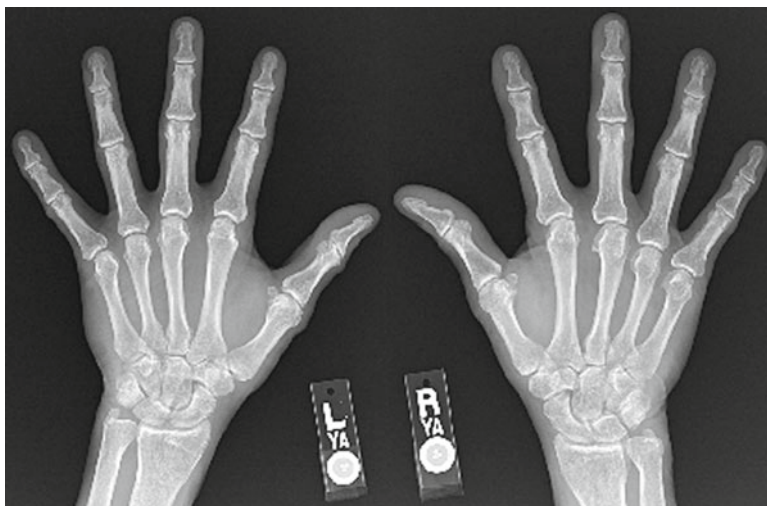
Osteophytes (right second DIP, bilateral fifth DIPs), degenerative joint disease without the presence of erosions (right second, third, and fourth DIPs), and joint space narrowing (bilateral first MCPs and DIPs, bilateral fifth DIPs) are characteristics of osteoarthritis shown in these bilateral hand X-rays
